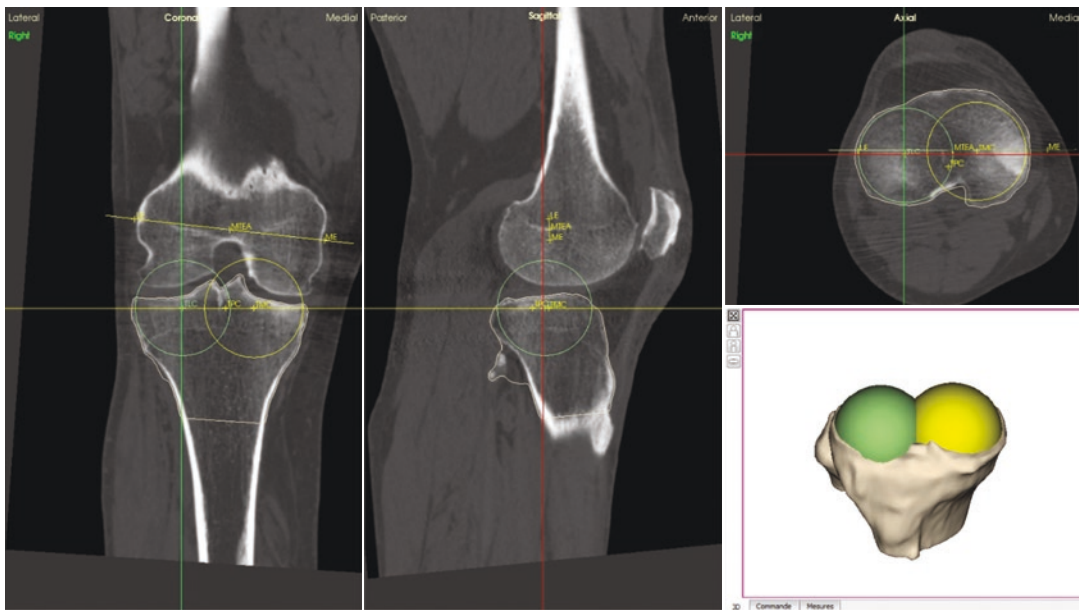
CT slices of a patient's knee and a sphere placed on the lateral tibial condyle
